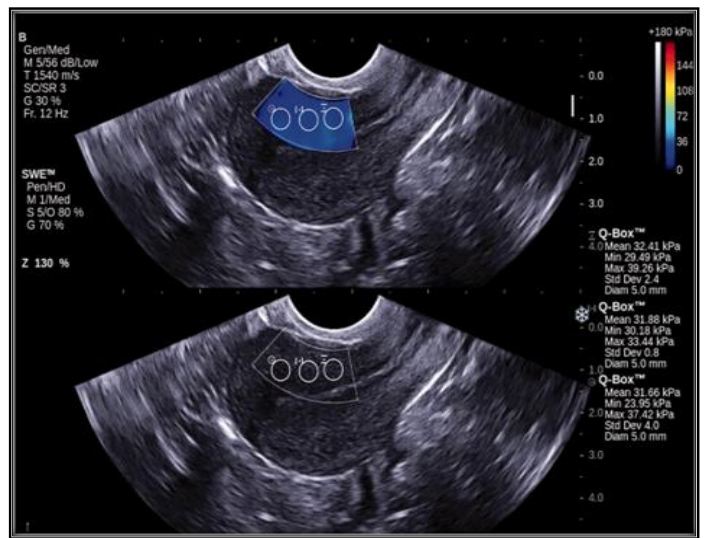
ultrasound shear wave elastography in uterine fibroids
